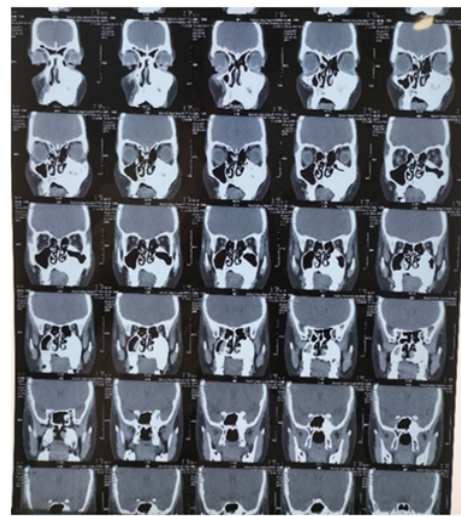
CT image of the lesion.
